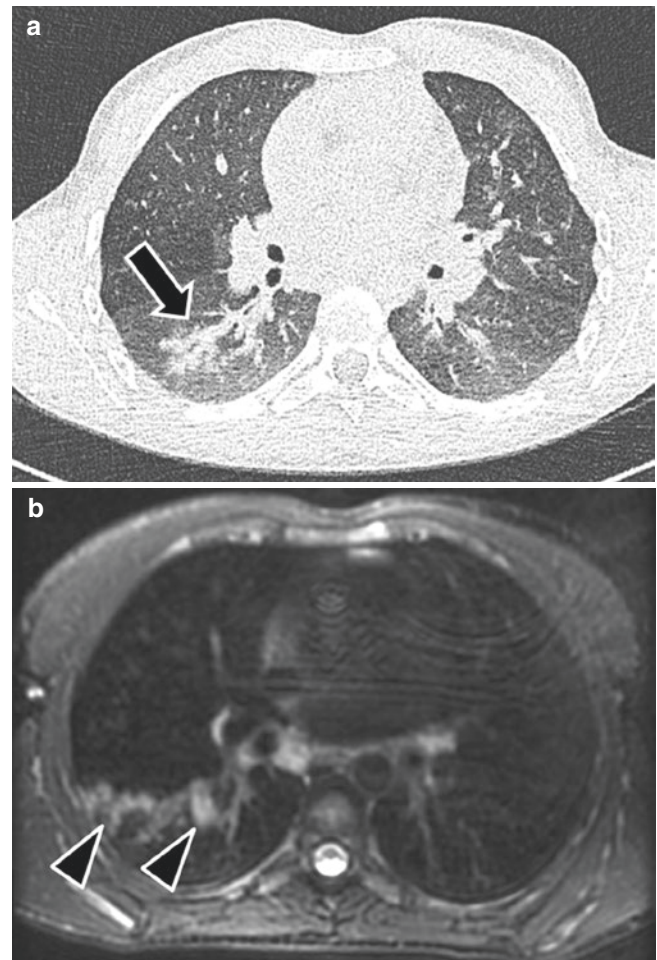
A 12-year-old boy with cystic fibrosis and *Aspergillus* infection. (a) Axial non-enhanced lung window setting CT image shows right lower lobe bronchiectasis containing impacted material (arrow). (b) Axial T2-weighted MR image with fat suppression shows right lower lobe bronchiectasis containing impacted hyperintense mucus (black arrowheads) due to *Aspergillus*
